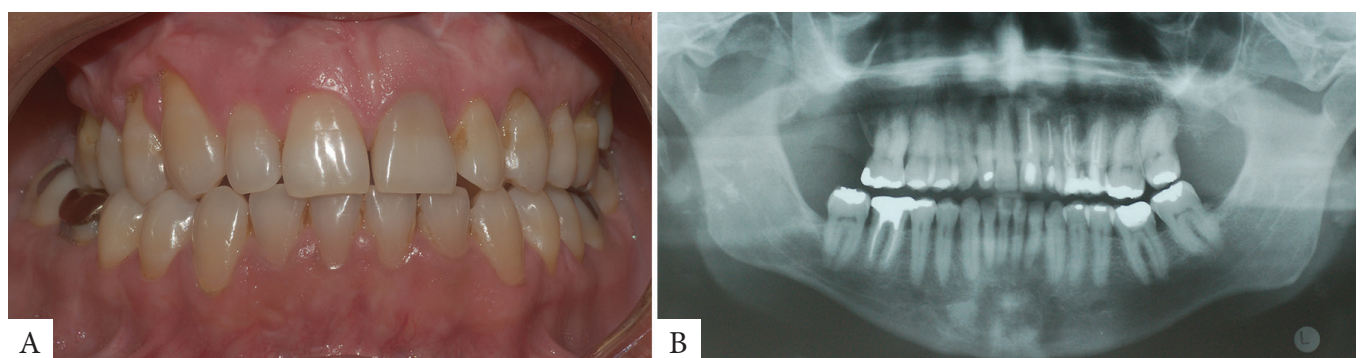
Clinical (A) and radiographic (B) images showing no recurrence of KOT.
